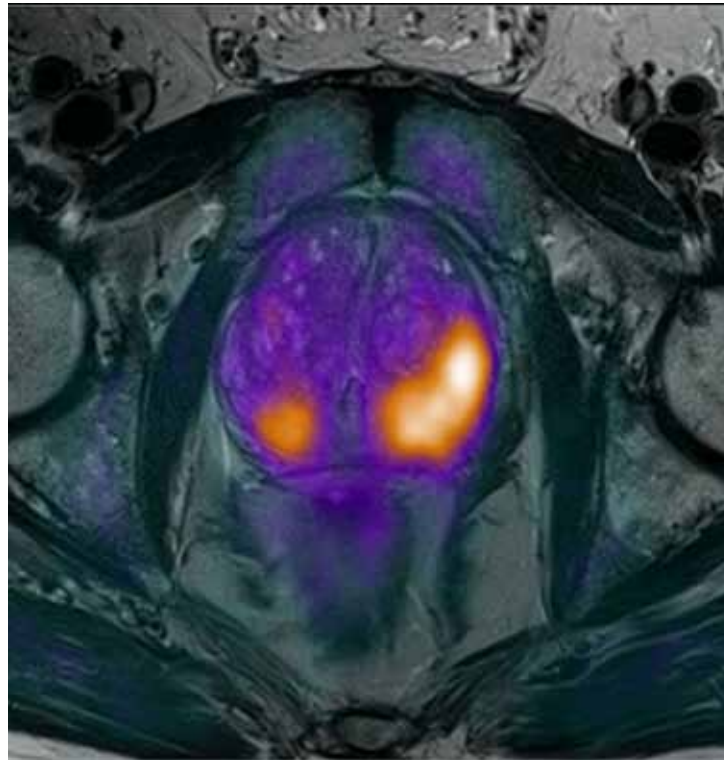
PET-MR image of the prostate in a patient with suspected prostate cancer showing both lobes are affected (left > right). By combining PET and MRI data, a more accurate delineation of prostate cancer is possible
